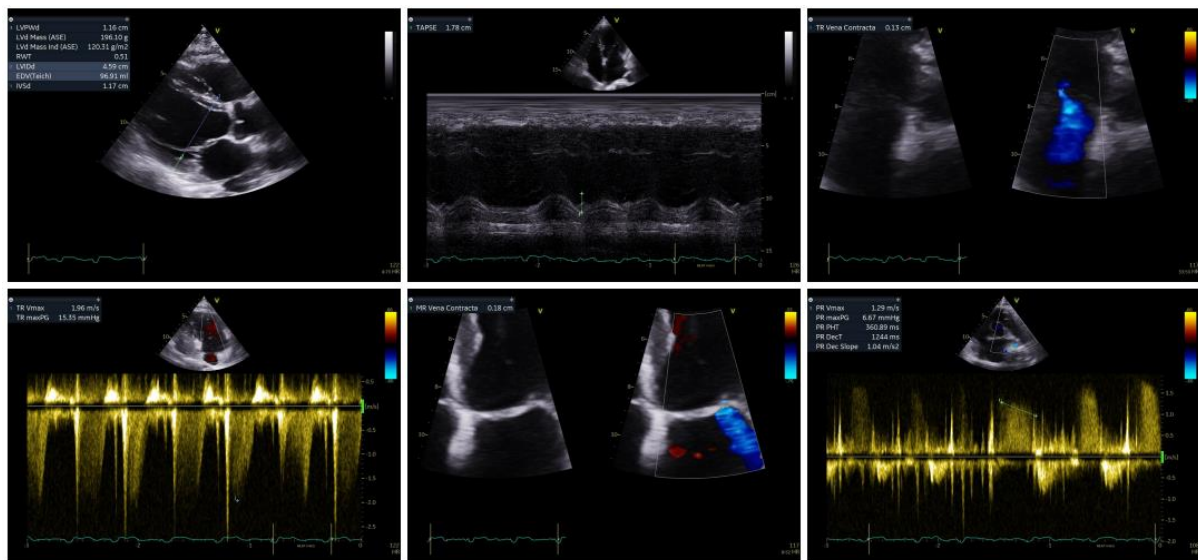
Echocardiography Record of the Patient
